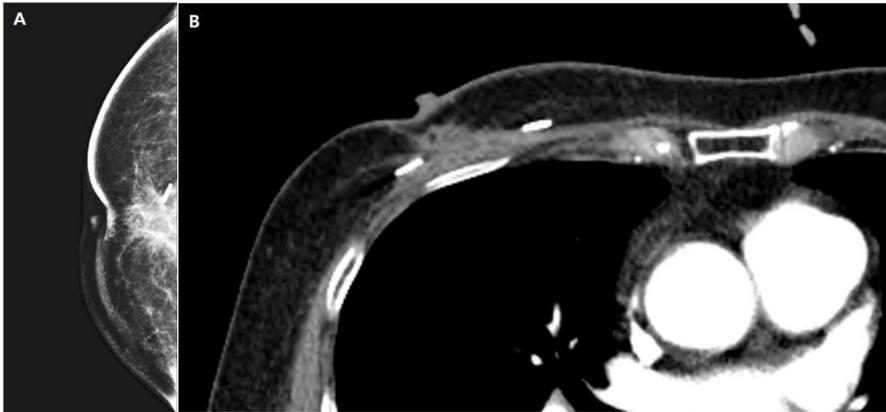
A: Mammography showing postoperative changes in the right breast consistent with breast-conserving surgery, B: Chest CT showing resection of abnormal breast tissue in the right breast, with surgical clips visible at the operative site corresponding to the findings on mammography
